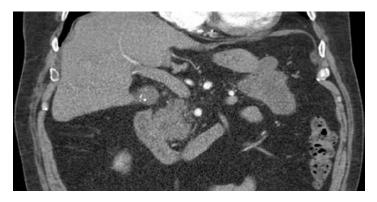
CT demonstrating mass in the pancreatic head
